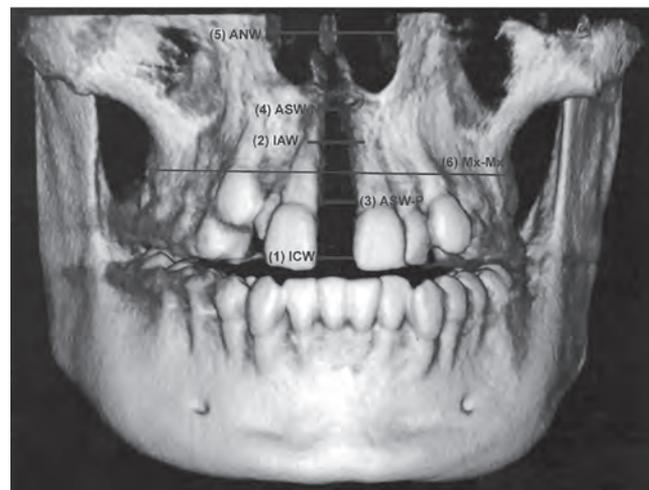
Measurements taken on computed tomography after the rapid maxillary expansion procedure. Source: Bilgiç et al.¹, 2017.
